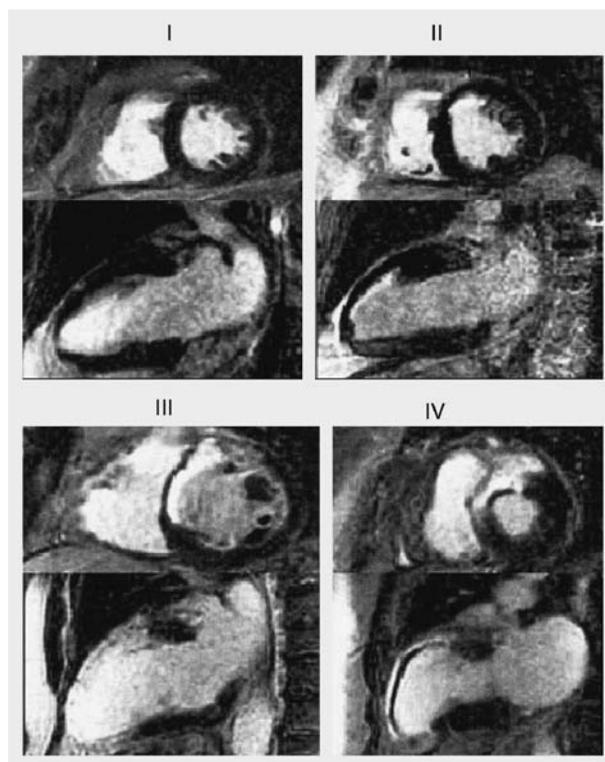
Typical examples of the different tissue reperfusion scores detected by contrast-enhanced magnetic resonance imaging (ceMRI) in patients undergoing primary percutaneous coronary intervention at increasing time delays from the onset of chest pain (see text for details). Upper and lower panels respectively show results of ceMRI obtained at the short-axis level and in the long-axis two-chamber plane. I: Anterior ST-segment elevation myocardial infarct (STEMI); pain to balloon time 70 min; troponin I peak 11.7 ng/mL. At 6 days from the acute event, no signs of necrosis are evident on ceMRI ("aborted" infarct). II: Anterior STEMI; pain to balloon time 170 min; troponin I peak 38.6 ng/mL. At 6 days from the acute event, ceMRI shows a non transmural necrosis in the middle and apical segments of the anterior wall. III: Anterior STEMI; pain to balloon time 240 min; troponin I peak 199 ng/mL. At 8 days from the acute event, ceMRI shows a transmural necrosis of more than two ventricular segments, without evidence of severe microvascular damage. IV: Anterior STEMI; pain to balloon time 310 min; troponin I peak 258 ng/mL. At 7 days from the acute event, ceMRI shows transmural necrosis of more than two ventricular segments, with evidence of a subendocardial dark zone referred to as severe microvascular obstruction. (Modified from Tarantini G et al [3], with permission. © Elsevier).
